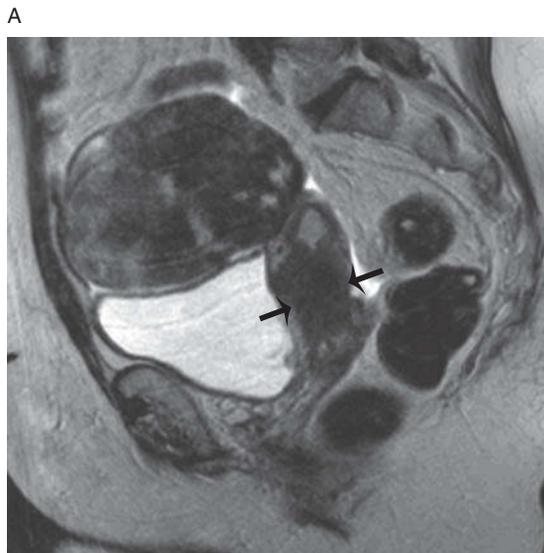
Stage IIB cervical carcinoma in a 72-year-old female. Sagittal T2-weighted image (A) demonstrates a low T2 signal intensity cervical mass with superior extension along the uterine body (arrows). Also incidentally seen superior to the uterus is a right ovarian fibroma. Corresponding oblique axial T2-weighted image (B) at the level of the cervix further demonstrates extension of the mass into the parametrium (arrows), right greater than left.
